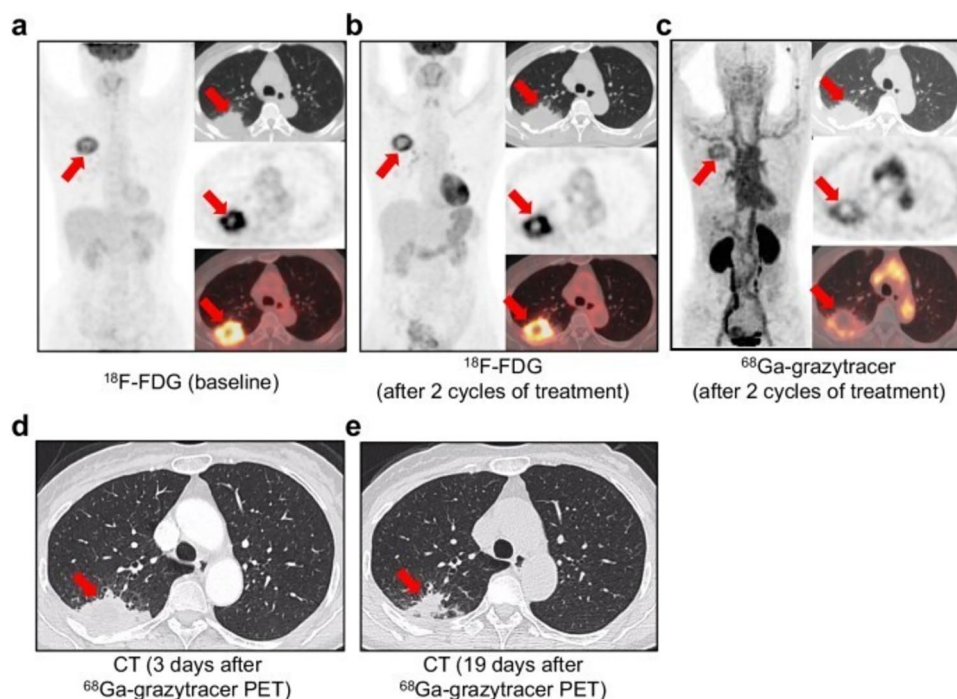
a Baseline [^{18}F]FDG PET/CT demonstrated a mass in the right upper lung lobe, showing intense [^{18}F]FDG uptake (SUVmax 7.6). b After two cycles of combined immunotherapy and chemotherapy, [^{18}F]FDG PET/CT showed no change in tumor size; however, metabolic activity had increased compared with baseline (SUVmax 11.3 vs. 7.6). c [^{68}Ga]Ga-grazytracer PET/CT performed after two treatment cycles identified the right upper lobe mass with heterogeneously elevated tracer uptake (arrows; SUVmax 5.2). d Chest CT obtained 3
